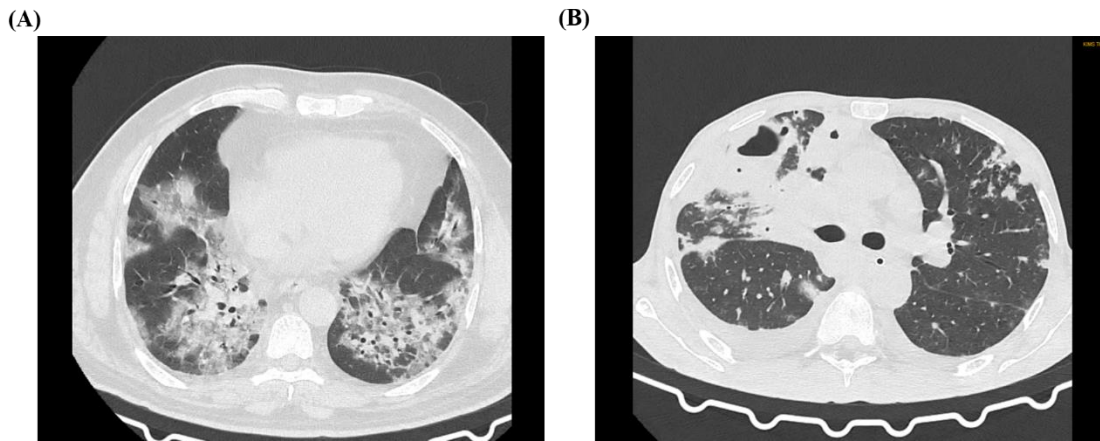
CT thorax of Cancer-COVID patients. The representative CT image of Cancer-COVID patients. (A) CT thorax of patient 4 (lung cancer). The image showing Bilateral peripheral and centrilobular ground glass opacities with consolidation. (B) CT thorax of patient 5 (cancer of hard palate). The image showing left sided peripheral ground glass opacities, right lung- consolidation with cavitation, interseptal and pleural effusion in addition to ground glass opacities. Both these patients were receiving chemotherapy at the time of infection and had CT severity score of 19/25.
